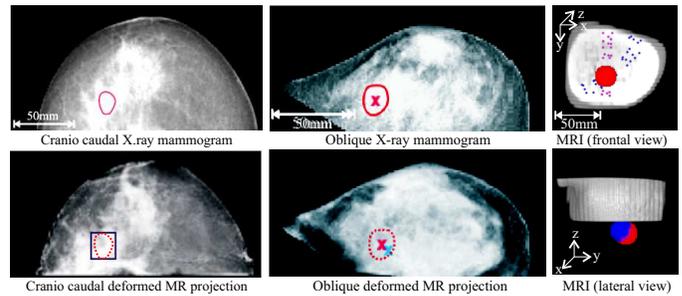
Exemplary localization results. First two columns show mammograms and the corresponding MR projections with lesion localization. The third column depicts the lesion localization in a MR image. The original lesions are depicted in red, the localization in blue.
